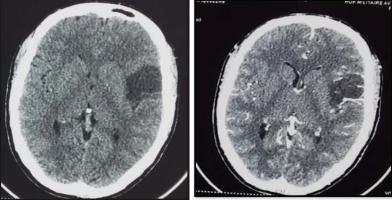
Brain CT with and without injection of iodinated contrast product: shows systematized hypodensity at the left fronto-insular level and the external capsule suggesting ischemic stroke in the territory of the left superficial Sylvian artery
